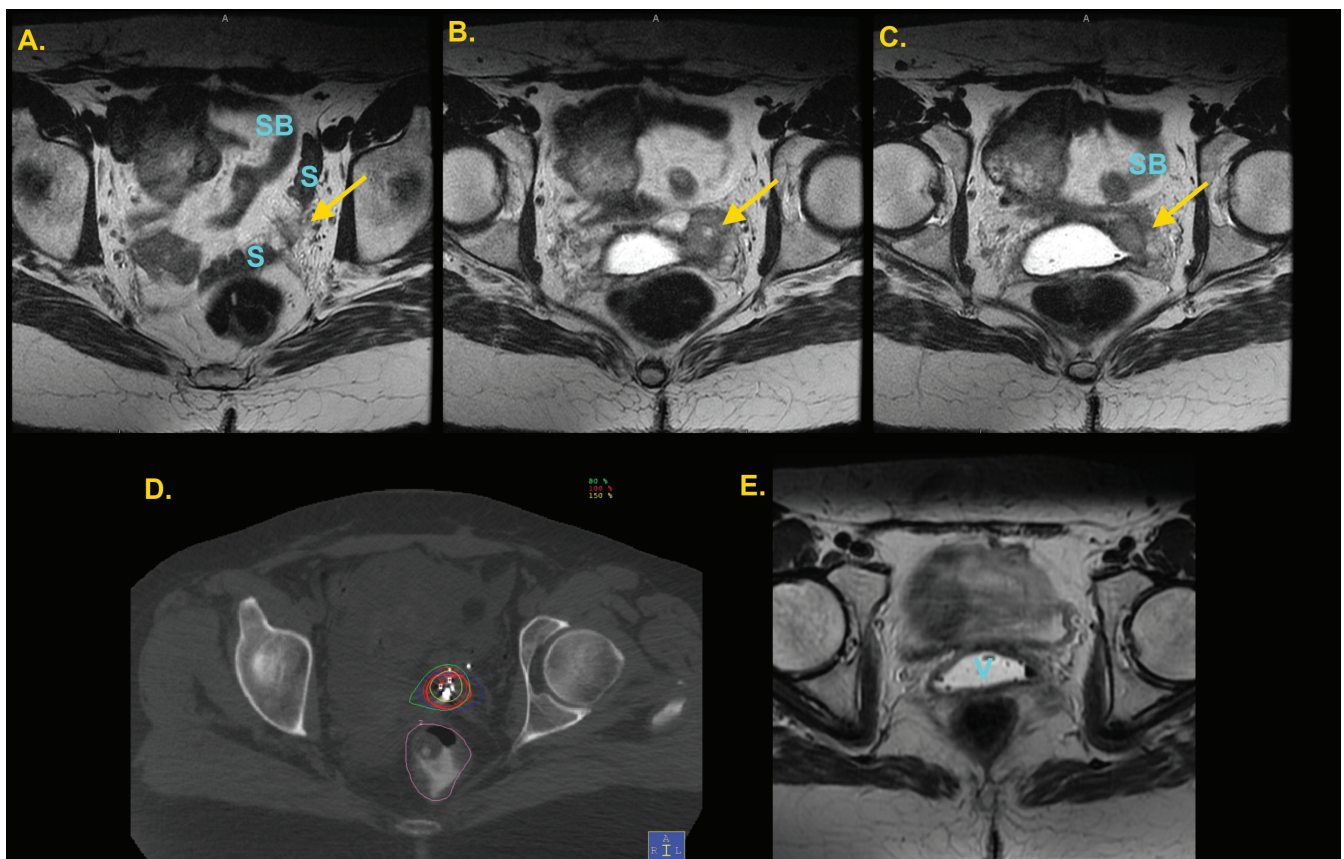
The images (A-C) are sequential pretreatment MRI slices from superior to inferior, demonstrating the mass (arrow) in the left adnexa abutting the sigmoid colon superiorly and extension into the vagina inferiorly. Image D is the treatment planning CT scan for the HDR brachytherapy component of her care. Image E is the follow-up MRI demonstrating a complete clinical response (SB = small bowel, S = sigmoid colon, V = vagina).
